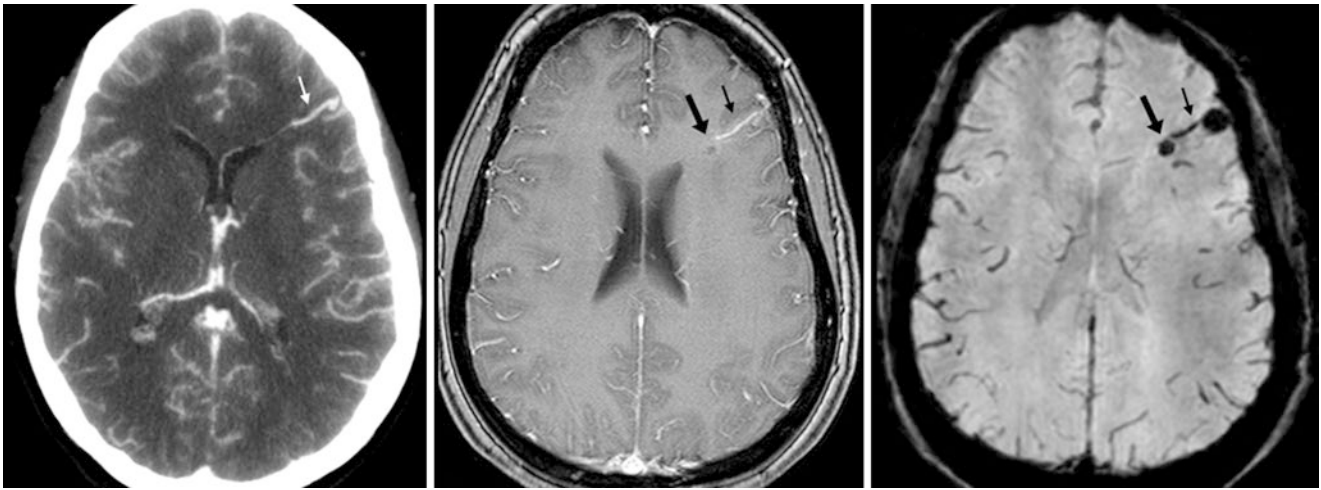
Comparison case of cavernoma. A 40 year old had focal left frontal subarachnoid hemorrhage that was initially noted on NECT (*not shown*). A CT venogram (*left*) demonstrated an enlarged draining vein (*thin arrows*). A subsequent catheter angiogram was negative. On
